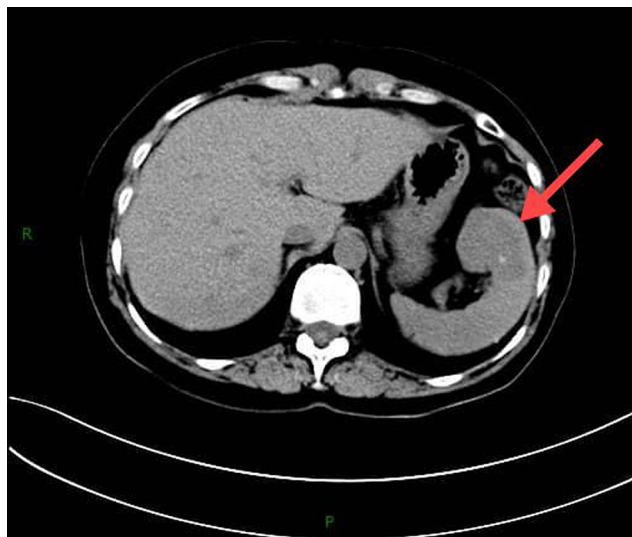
Computed tomography showing isolated, well-demarcated, low-density, oval foci with occasional calcification (red arrow)
